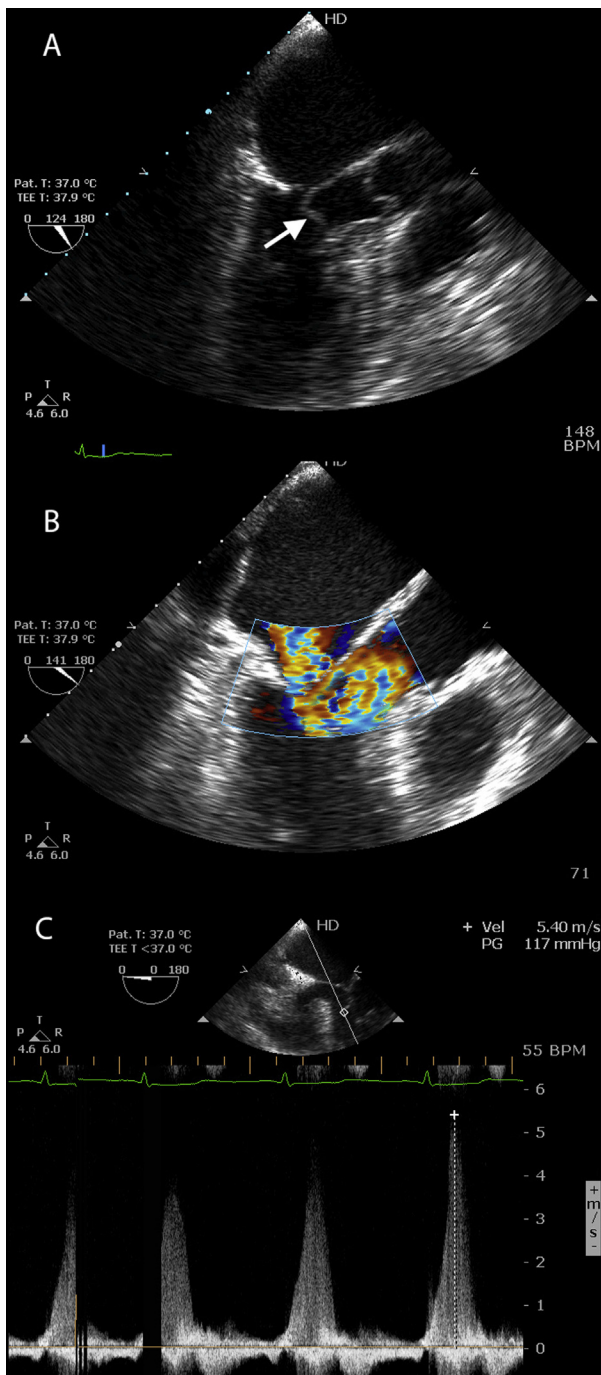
Characteristic appearances of SAM after MV repair. (A) With 2D imaging, there is characteristic bending of the anterior mitral leaflet (arrow) into the LVOT (late systole, midesophageal long-axis view). (B) With color flow Doppler imaging, there is marked turbulence in the LVOT, and a broad jet of MR is seen (late systole, midesophageal long-axis view). Although not obvious in this view, the regurgitant jet is usually posteriorly directed. (C) On continuous-wave (CW) Doppler imaging, a narrow, high-velocity (5.4 m/sec) regurgitant jet is seen, characteristic of SAM (late systole, midesophageal five-chamber view). Although not apparent in this view, the regurgitant jet is typically late peaking (i.e., maximal in late systole). Note that because the regurgitant jet is shown in the midesophageal five-chamber view, the CW signal is shown above the baseline (i.e., toward the transducer).
